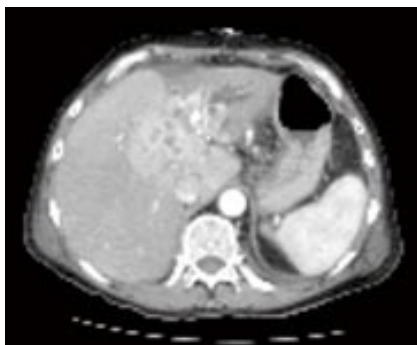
CT scan shows Klatskin tumor type III b with intrahepatic bile duct enlargement, cholestasis and atrophy of the left hepatic lobe.
